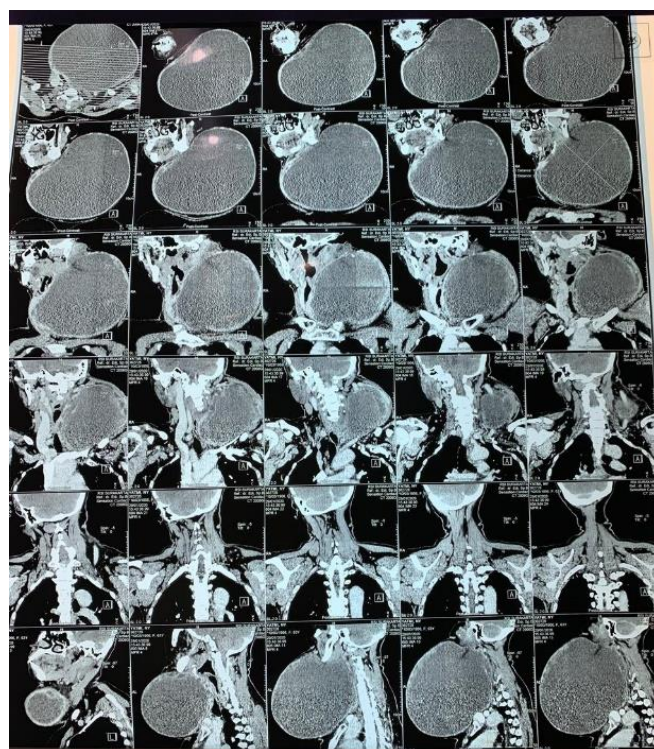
CT-scan of Colli
